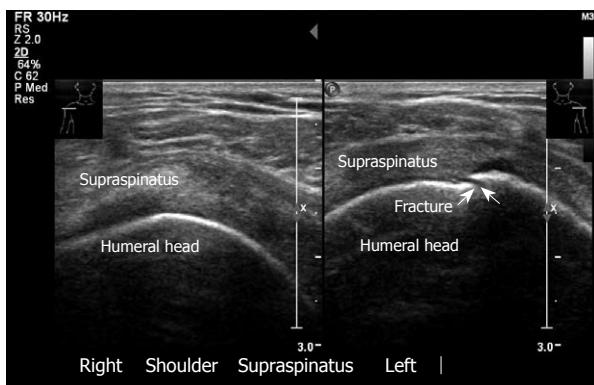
Fracture of greater tuberosity, left. Note the discontinuity of the bone. The right shoulder has normal appearance. Transverse sonogram.
